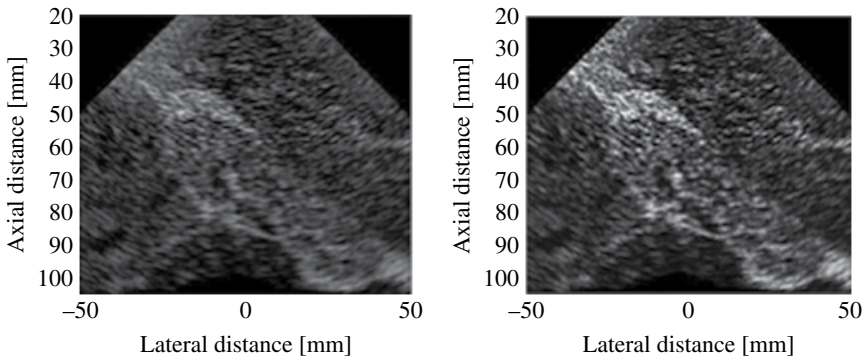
Preliminary results at the output analog front end (before digital display) from the ultrasound platform implementation on Matlab to demonstrate different noise injects caused differences in displays [31].
